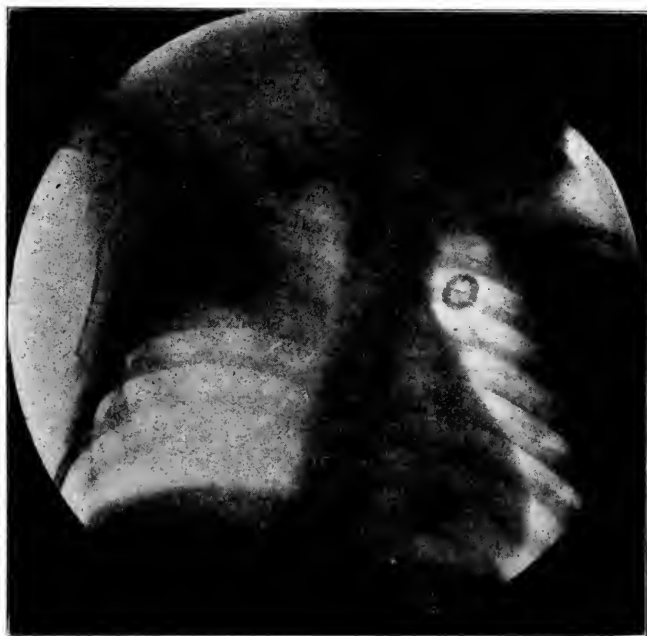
X-ray of Case 2, the day following admission to the hospital, showing a diminution in the area of pneumonia.
